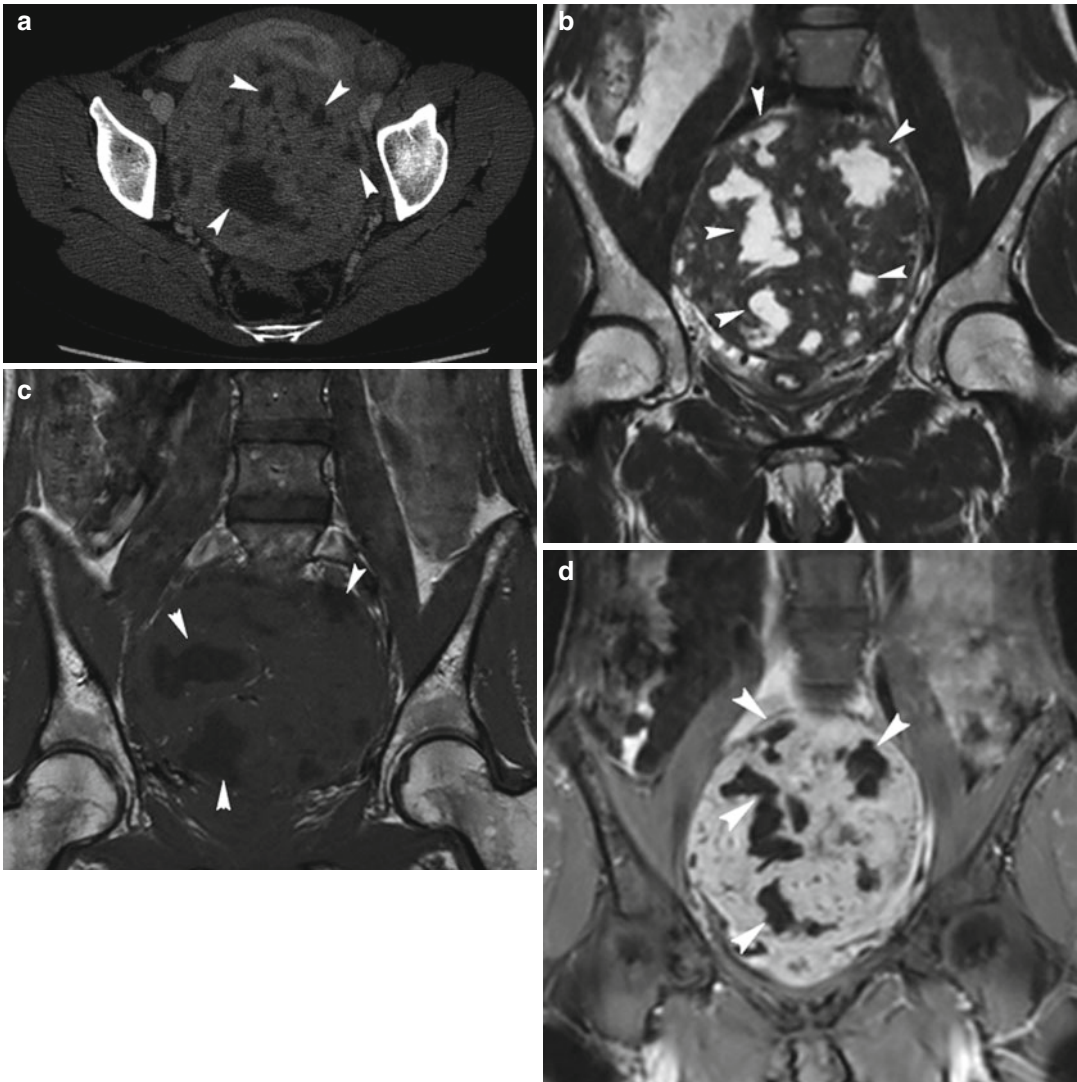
Fibroid with cystic degeneration. Axial CT scan (a) shows a large uterine mass with some not-enhancing liquid areas. MRI confirms the presence of a large intramural fibroid with several areas in cystic degeneration; these areas demonstrate very high signal intensity on T2-weighted image (TR 4,300 ms, TE
